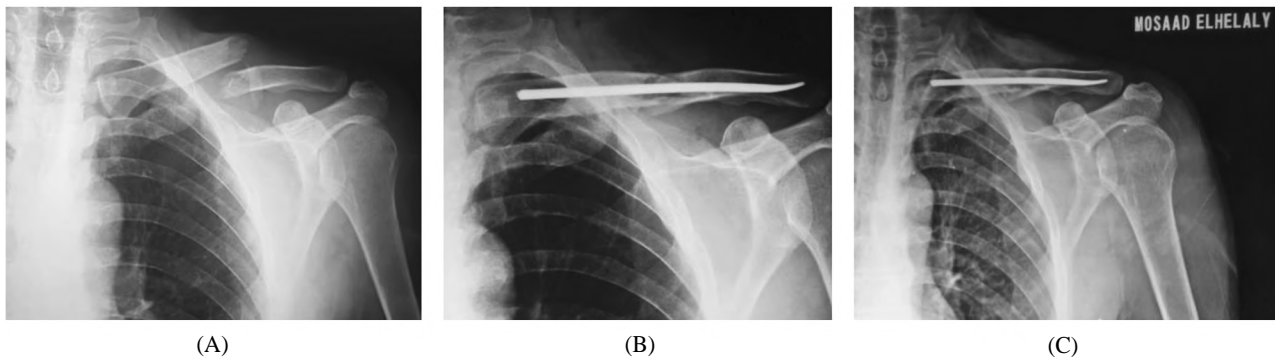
(A): Preoperative X-ray. (B): Immediate post-operative. (C): X-ray after six months.
